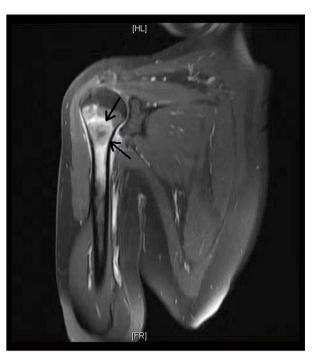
Magnetic resonance imaging of right upper extremity showing a right humeral intramedullary mass.
